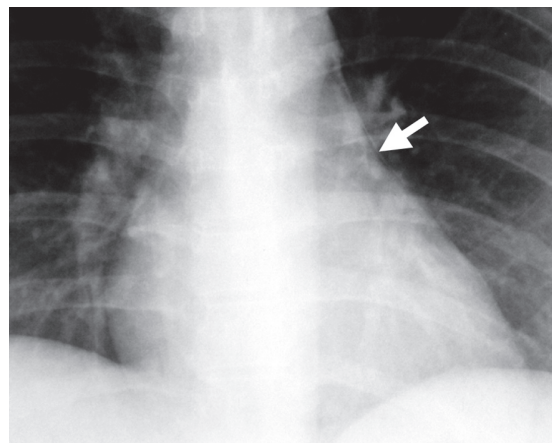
Frontal chest radiograph (coned view) shows the pneumomediastinum (arrow).
